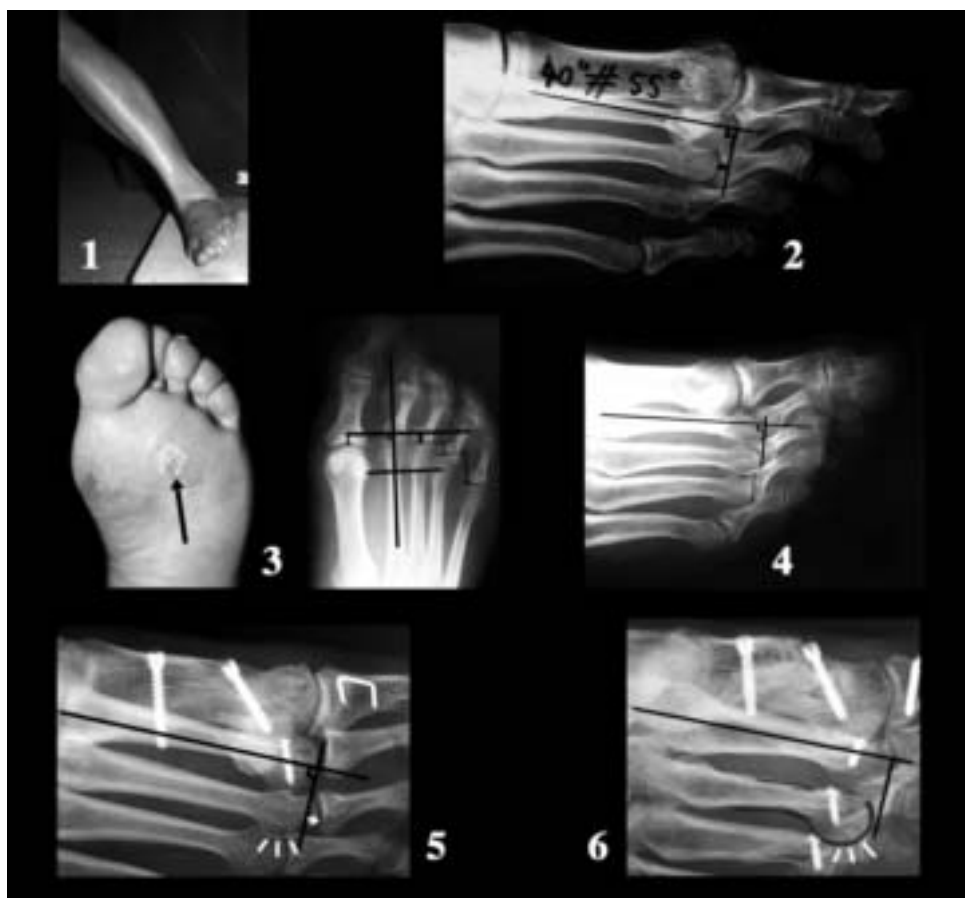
30a5c. Metatarsalgia – Main causes: (4) Metatarsal excess of length b) In a Medial X-ray oblique view.
